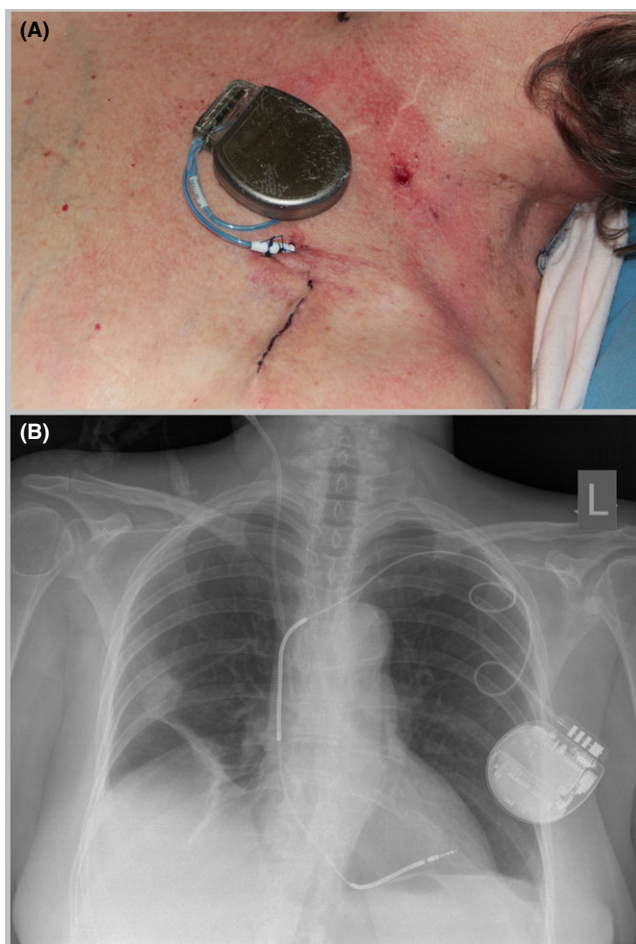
A, ICD lead implanted via a percutaneous puncture of the left subclavian vein, sutured to the skin, and connected to ICD unit; B, Chest x-ray after lead extraction and temporary dual-coil ICD lead implantation
